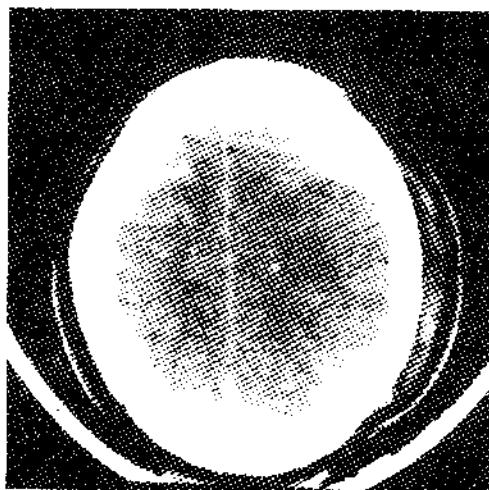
CT scan showing multiple petechial haemorrhages
